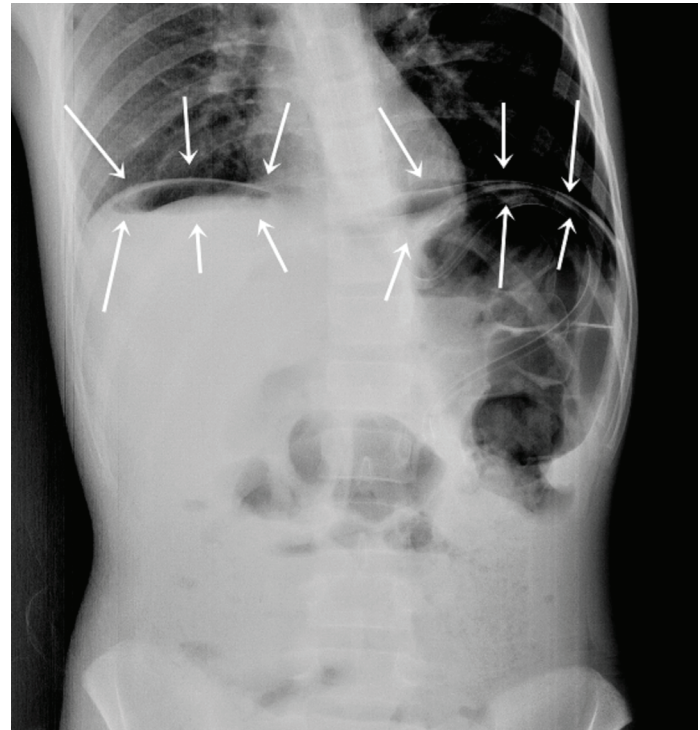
Abdominal plain radiograph image of a 13-year-old male patient. Free air (Arrows) continued to exist due to complications on the 6th day after appendectomy.
